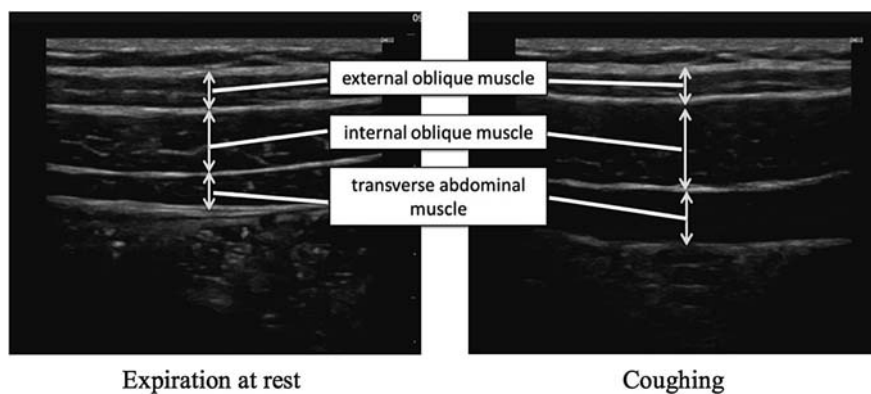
The measurement of expiratory muscle thickness by ultrasonic diagnostic equipment
